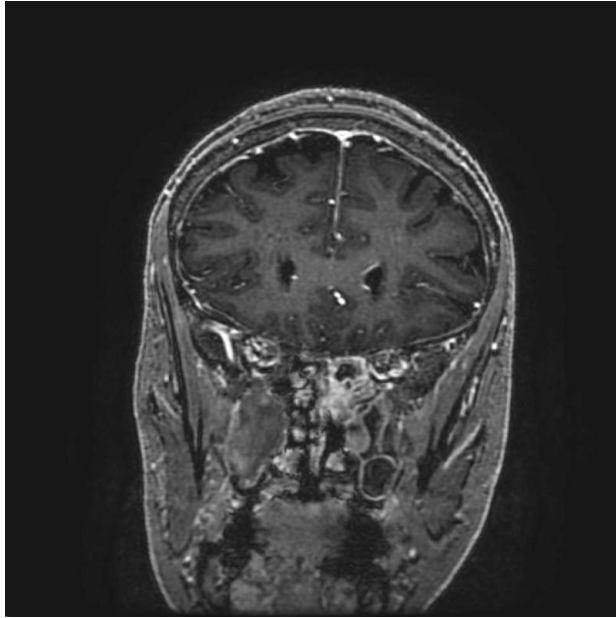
Contrasted MRI revealing increased enhancement of the left posterior ethmoid and sphenoid sinuses.
